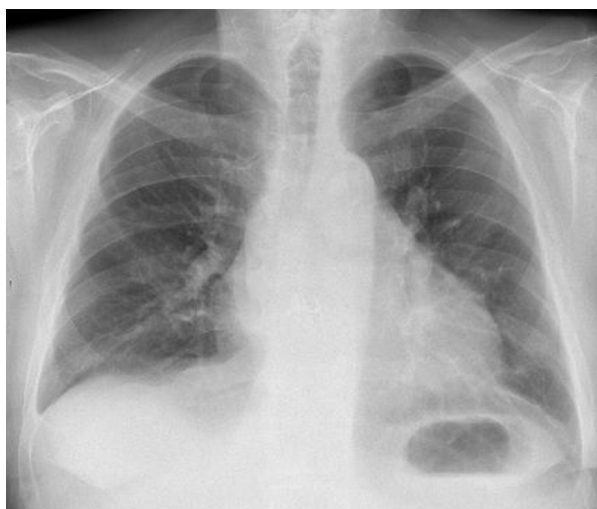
Postoperative chest radiograph showed clear lungs.
